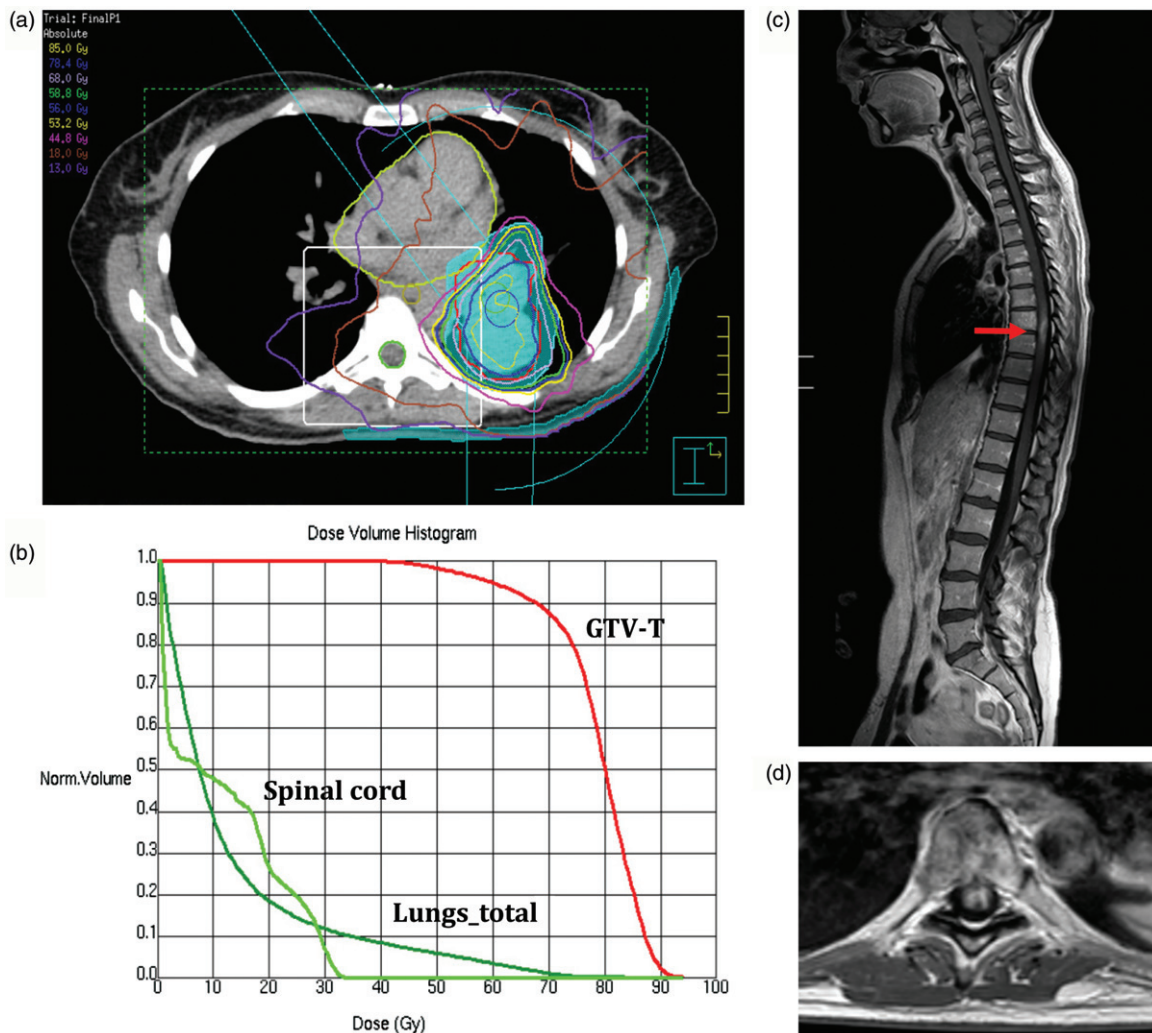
The CT-based plan of stereotactic radiotherapy showing isodoses (a), along with the dose-volume histogram – the pale green line showing absorbed dose by the spinal cord (b). Also, MRI after radiotherapy sagittal plane – arrow marking the affected area (c) and in the axial plane showing myelitis (d).
